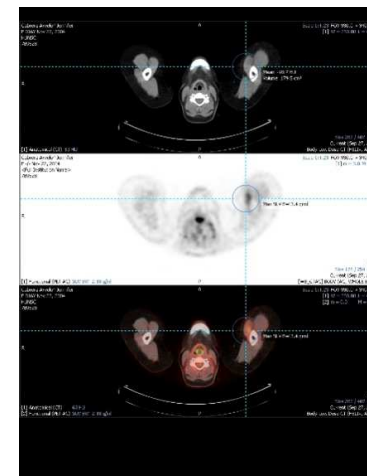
PET-CT is positive with increased FDG metabolism.
